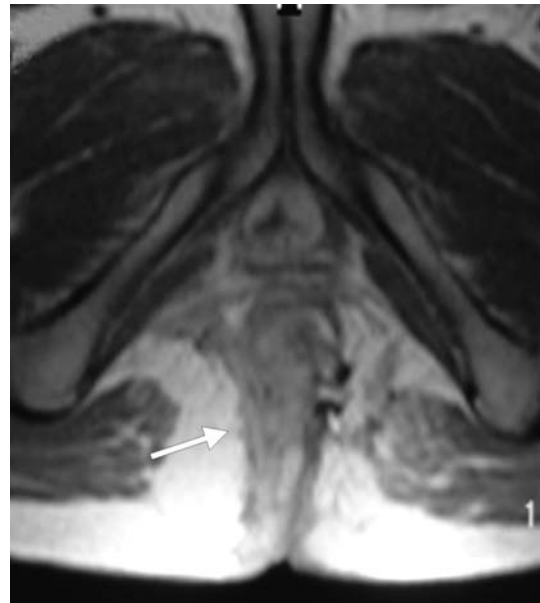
Axial T1-weighted MR image after administration of intravenous administration of contrast medium shows a right-sided transsphincteric fistula (*arrow*) penetrating and both sphincteric layers and tracking posteriorly to the right ischioanal fossa.
